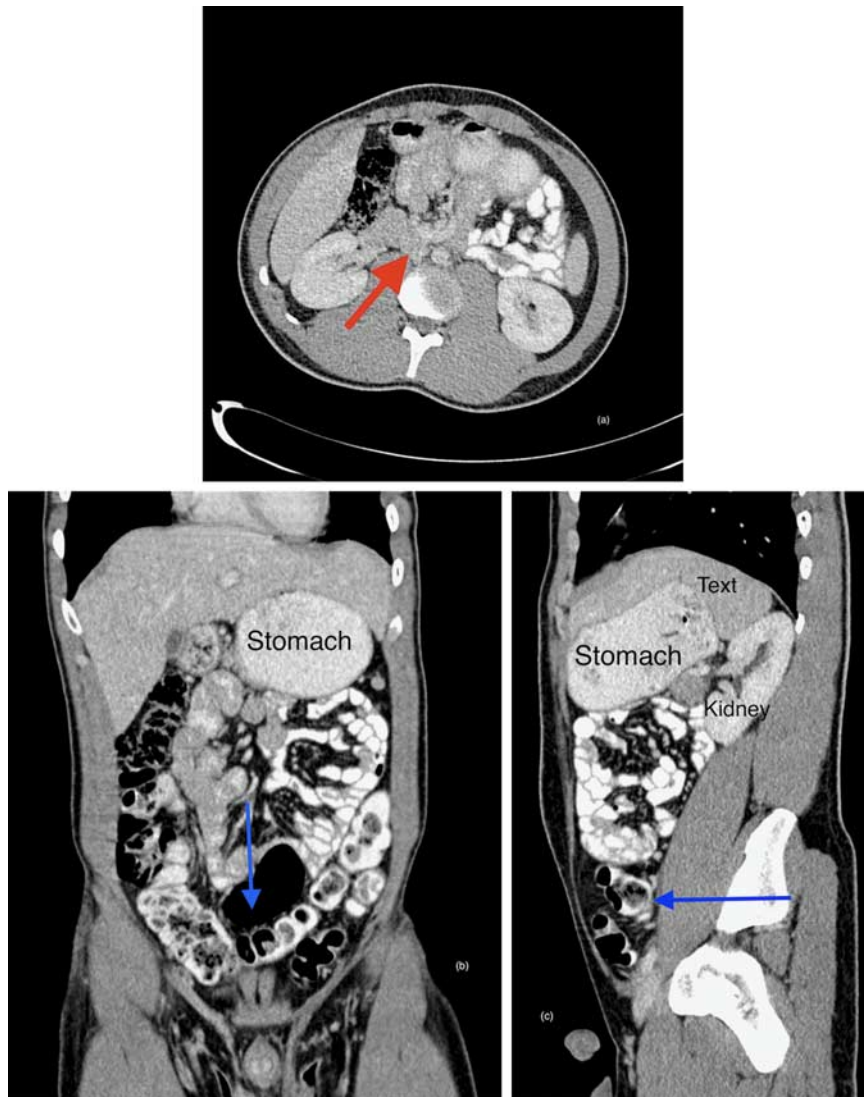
Computed tomographic scan of our patient. The images show an almost complete retroperitoneal herniation of the small bowel into the lesser sac (red arrow: hernial port). The transverse colon appears markedly pushed downwards and forward from the small bowel mass (blue arrows).
